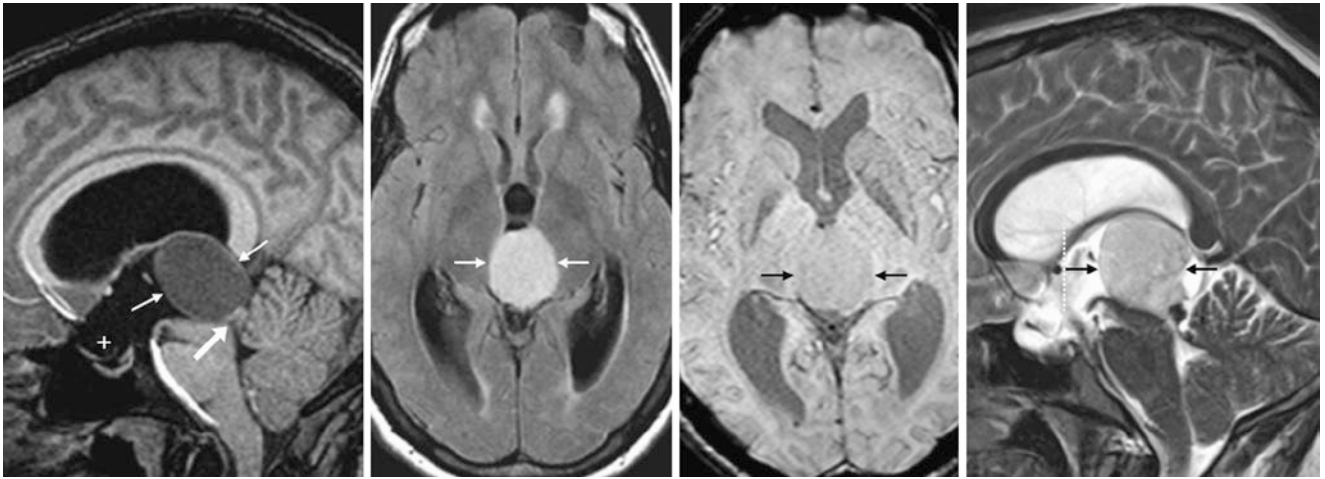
Companion case of a complex pineal cyst. A 24-year-old patient had a nonenhancing 3-cm cyst (*thin arrows*) and hydrocephalus. Note the enlarged optic recess of the third ventricle (+) on sagittal T1WI (*left*) and axial FLAIR (*left middle*), indicating hydrocephalus.
